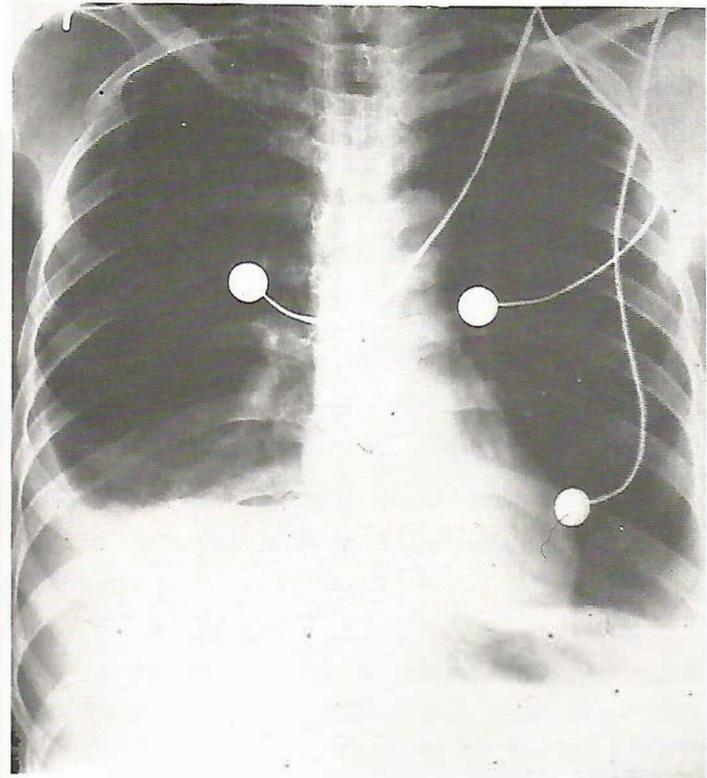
Post-operative X-Rays chest showing elevation of Rt. hemidiaphragm.
